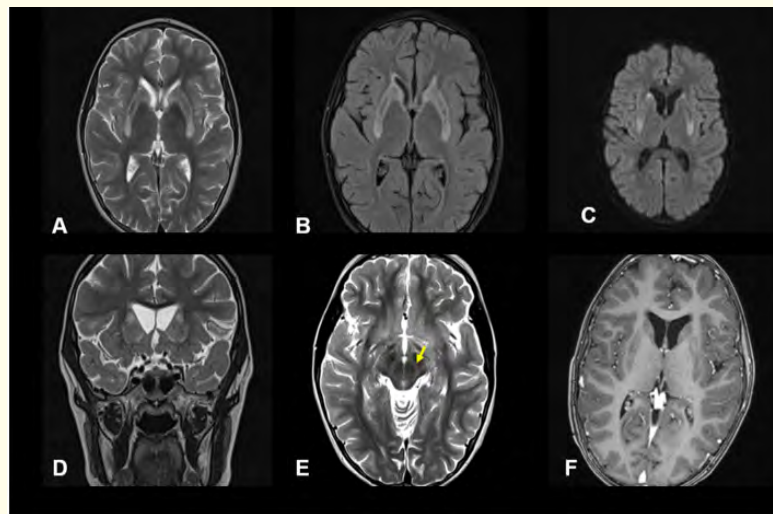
MRI of the brain: Axial T2-weighted image (A) and coronal FLAIR image (B) show bilateral hyperintensity of the caudate nuclei and putamina. Diffusion-weighted imaging (C) demonstrates restricted diffusion, indicating active lesions. Axial T2-weighted image (E) reveals the characteristic “face of the giant panda” sign in the midbrain, with preserved signal in the red nuclei and high signal in the tegmentum (arrow). No post-contrast enhancement is observed following gadolinium administration (F).
